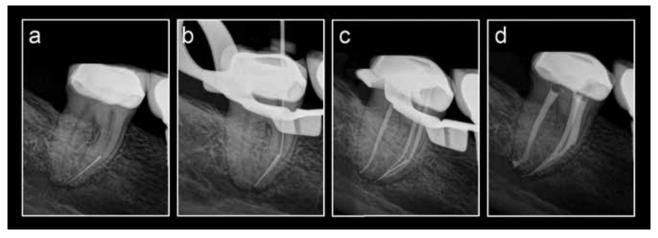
(a) Pre-operative peri-apical radiograph of a mandibular right second molar with a fractured instrument in the mesio-buccal root canal system; (b) Fractured file bypassed with a size 08 K-File; (c) TruNatomy Prime gutta percha points fitted after preparation with the TruNatomy Prime and Medium files; (d) Postoperative peri-apical radiograph after obturation
